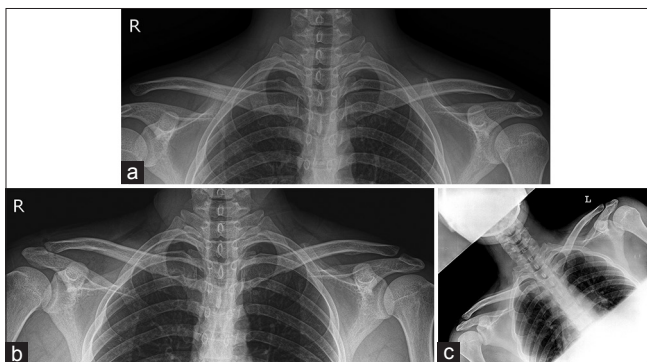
(a) Anteroposterior standing radiograph with the stress maneuver of 19-year-old male patient shows the right AC joint separation with Type V before the operation, (b) which is reduced by option A procedure, (c) and maintained well with calcification under the lateral resected clavicle at final followup
